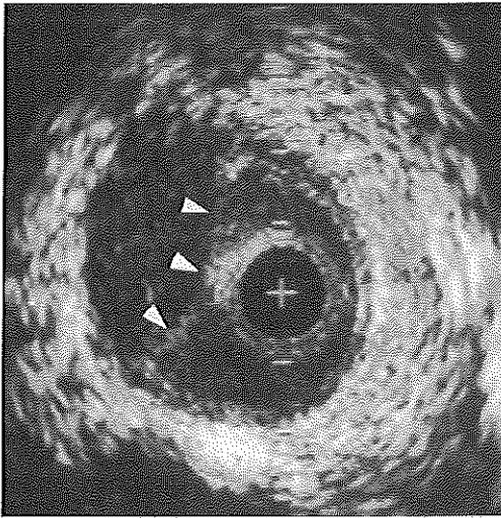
Intravascular ultrasound cross-section of a venous bypass showing a dissection of the vein wall (arrows). + = Catheter; calibration = 1 mm.
